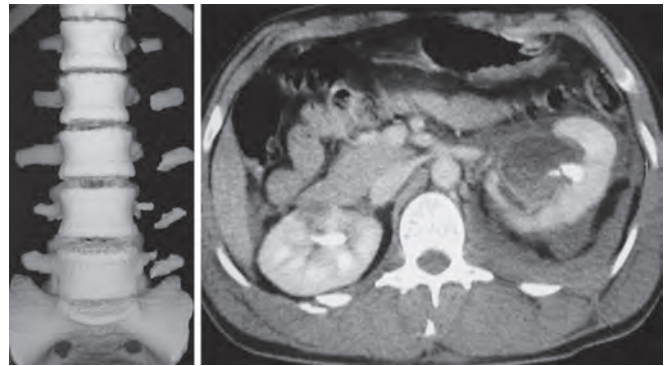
Multiple lumbar transverse process avulsion fractures on 3D CT reconstruction (left). Since it is a stable injury, this patient was treated with rest and analgesics, followed by lumbar corset use. Renal injuries are common with L1 transverse process fracture as seen in contrast CT of another patient (right)
